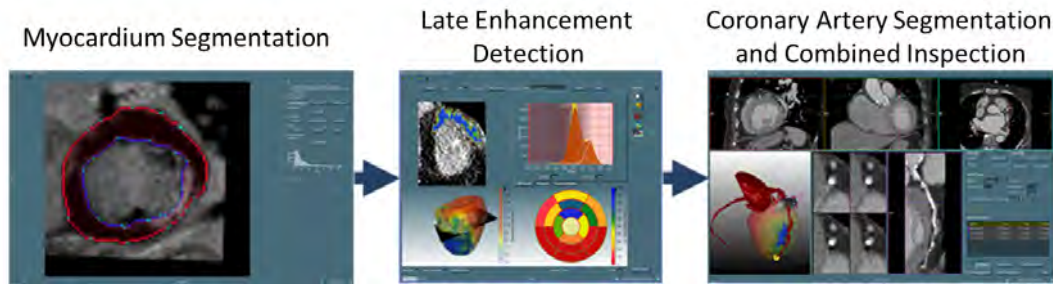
Prototype configuration for the combined analysis of CTCA and CT late enhancement
